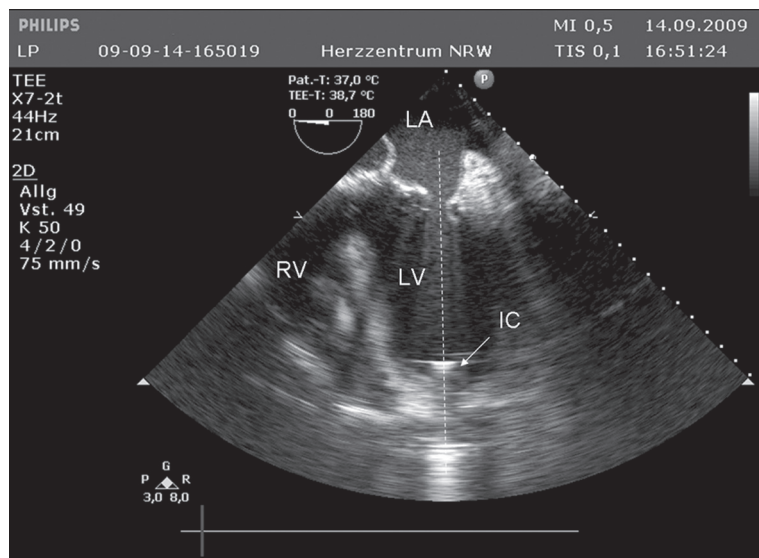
2-D transesophageal echocardiographic examination, 4 chamber view. The inflow cannula in the apex of the left ventricle. LA – left atrium, LV – left ventricle, RV – right ventricle, Arrow shows the inflow cannula – IC. Dashed line shows axis between inflow cannula and mitral valve.
